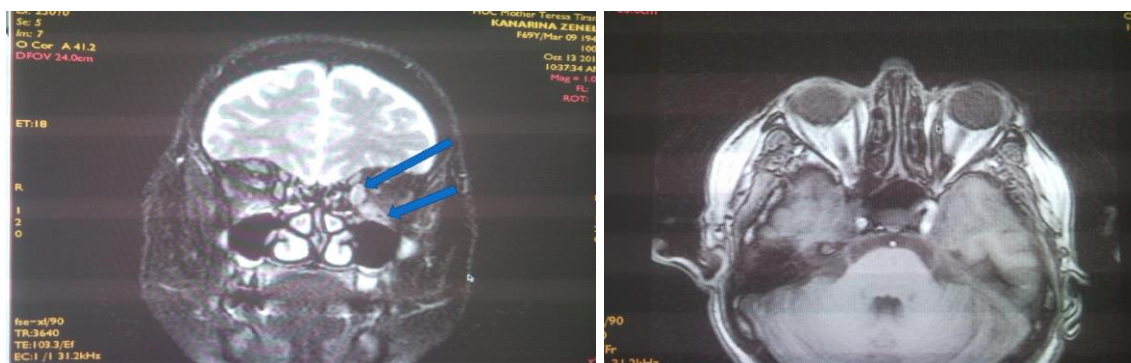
Orbit MRI revealed enlargement of medial rectus and inferior oblique muscles and hypertrophy of orbital fat.
